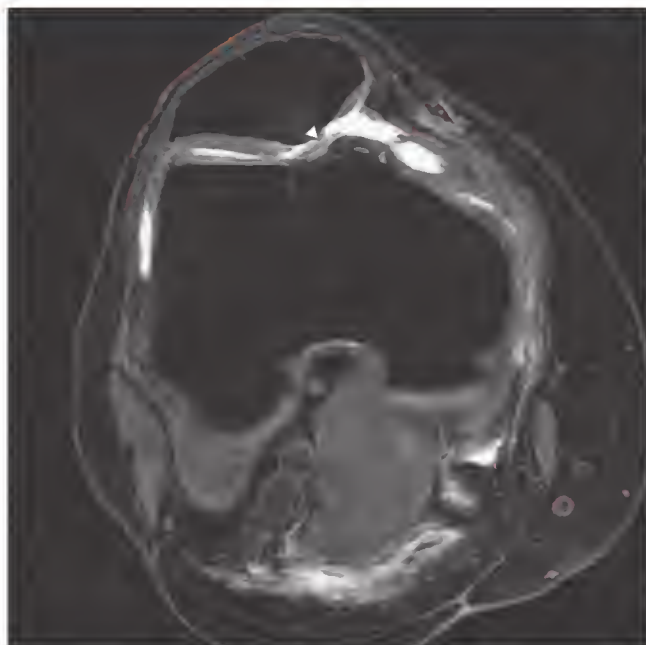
Axial T2-weighted fat-suppressed magnetic resonance image of the knee demonstrating cartilage loss over the crista and medial facet of the patella (arrowhead).
